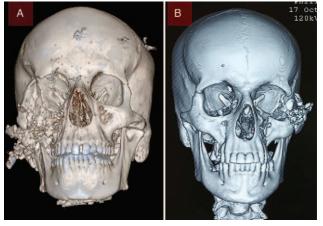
Three-dimensional computerized tomography (3D CT) showing comminuted fractures associated with bullets and blast injuries: (A) bullet injury, (B) blast injury.
